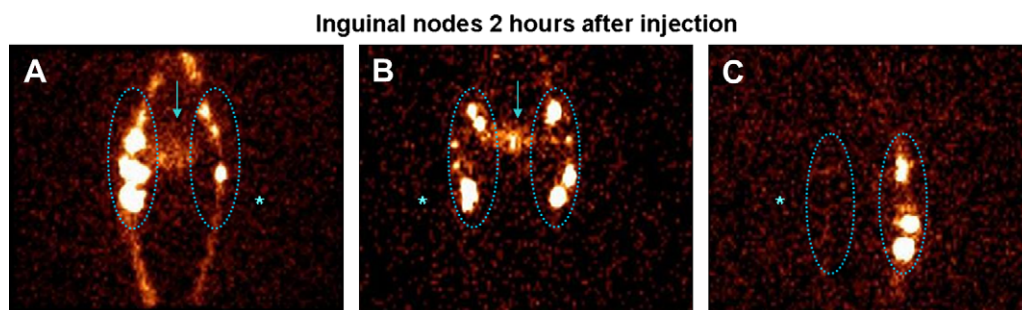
Lymphoscintigraphic evaluation in patients A, B and C. The asterisk (*) indicates the operated leg, the arrow (↓) points to the bladder. The panel shows radioactivity in the inguinal nodes 2 h after injection. In patient A, the uptake was normal on the right side (14%) and diminished on the left (operated) side (1.7%). Patient B had diminished uptake bilaterally, left 2.5%, and right 2.0%. Patient C also had bilaterally diminished uptake, left 4.4% and right 0.3%.
